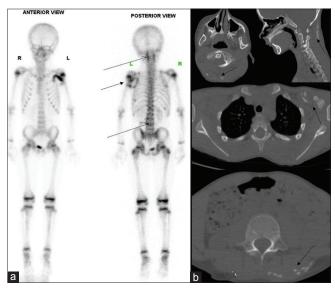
(a) Whole-body methylene diphosphonate bone scan images of case 2, with extraosseous increased soft-tissue tracer uptake in the neck posteriorly, around left shoulder joint and left scapula and within the erector spinae muscles at the level of L3-L4 vertebrae. Low dose Noncontrast computed tomography images (b) show soft-tissue calcifications and areas of neo-osteogenesis, corresponding to sites of increased methylene diphosphonate uptake in bone scan
